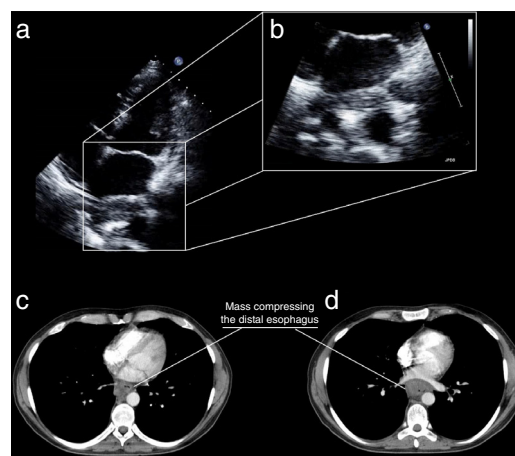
Top: transthoracic echocardiography, (a) apical 4-chamber view showing a mass to the rear of the left atrium and (b) zoom view on the mass; bottom: computed tomography of the chest, axial view, showing a mass constricting the distal esophagus.
